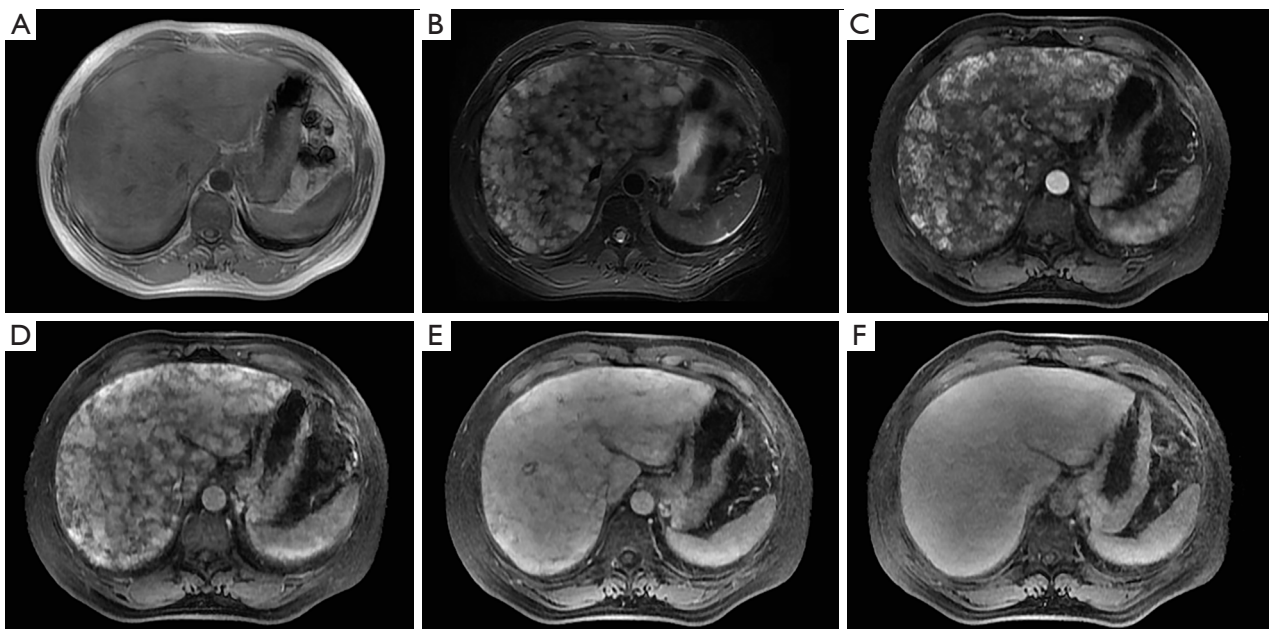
Contrast-enhanced magnetic resonance imaging. (A,B) Diffuse long T1 and long T2 signals. (C) The lesions were heterogeneously enhanced in the arterial phase, with the lace-like edge and thin strip or small round low signals in the center. (D) The lesions were still significantly enhanced with high signals and a reduced range of low signals within them in the portal phase. (E) Iso-signal lesions and multiple thin strips of low signals between lesions in the delayed phase. (F) The whole liver showed uniform signals 5 minutes after the contrast agent injection.
